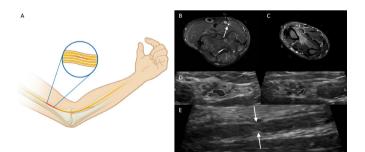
(A) In anterior interosseous syndrome, constrictions are most often found approximately 5 cm proximal to the elbow. Clinically, patients present with weak flexion of the distal phalanges of the first two fingers (A). Both MRI and HRUS were performed in a patient with idiopathic palsy of the anterior interosseous nerve. (B) Shows the hyperintense fascicle of the AIN within the median nerve at the upper arm (arrow) and (C) The concurring atrophy of the pronator quadratus muscle at the distal forearm. In (D) the fascicle of the AIN within the median nerve is visualised in HRUS, presenting enlarged on the right side (encircled in white), and in a longitudinal section of the same nerve (E) a constriction was detected (arrows). AIN, anterior interosseous nerve; HRUS, high-resolution ultrasound.
